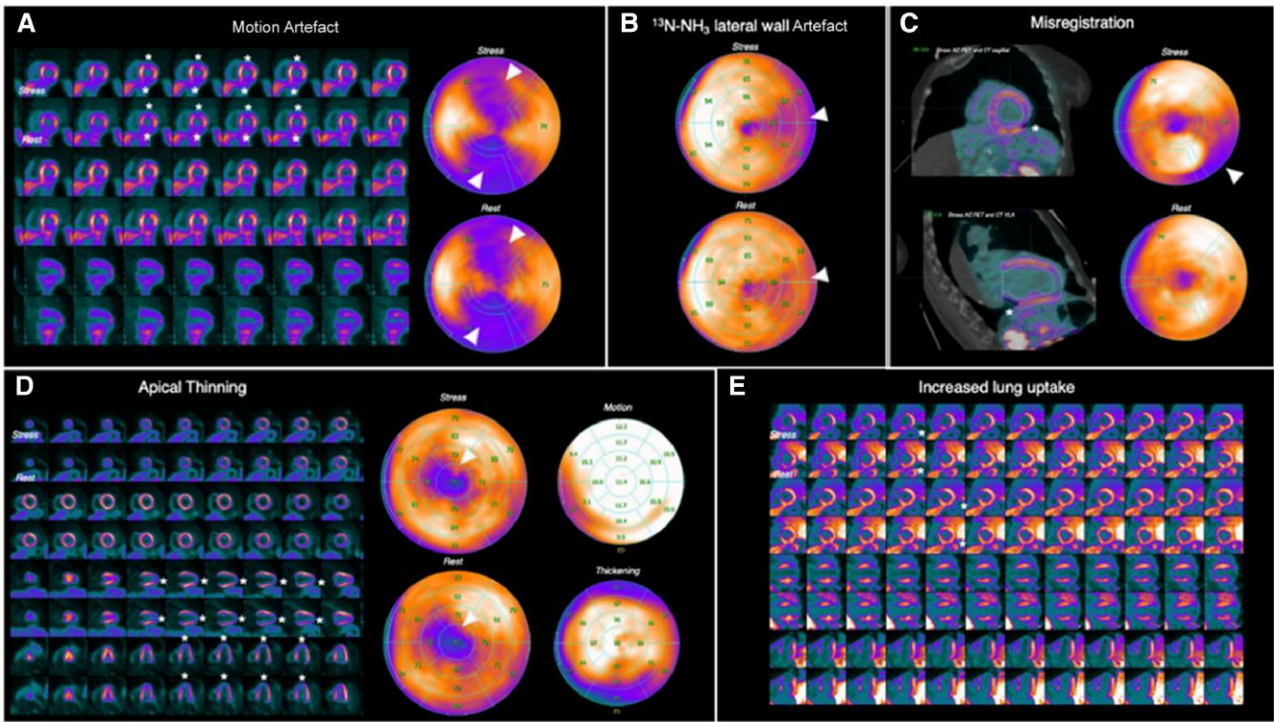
Demonstrative examples of the most common artefacts encountered at PET MPI. (A) Typical appearance of a motion artefact (butterfly appearance) evident at both stress and rest images of a restless patient with claustrophobia undergoing PET MPI. (B) Typical fixed lateral wall defect in a patient undergoing rest/stress ¹³N-NH₃ PET MPI. Note that the defect is more evident at stress due to higher tracer dose applied. (C) Mis-registration of the stress PET images with the CT transmission images resulting in a reversible perfusion defect at the inferolateral basal wall. (D) Typical apical thinning defect at a patient undergoing PET MPI with normal wall motion and thickening. (E) Increased lung uptake at a patient undergoing rest/stress ¹³N-NH₃ PET MPI directly after cigarette smoking. Note the more prominent extracardiac uptake during rest. Asterisks depict the artefact at the slices, and arrow heads depict the corresponding artefact appearance at the polar plots.
